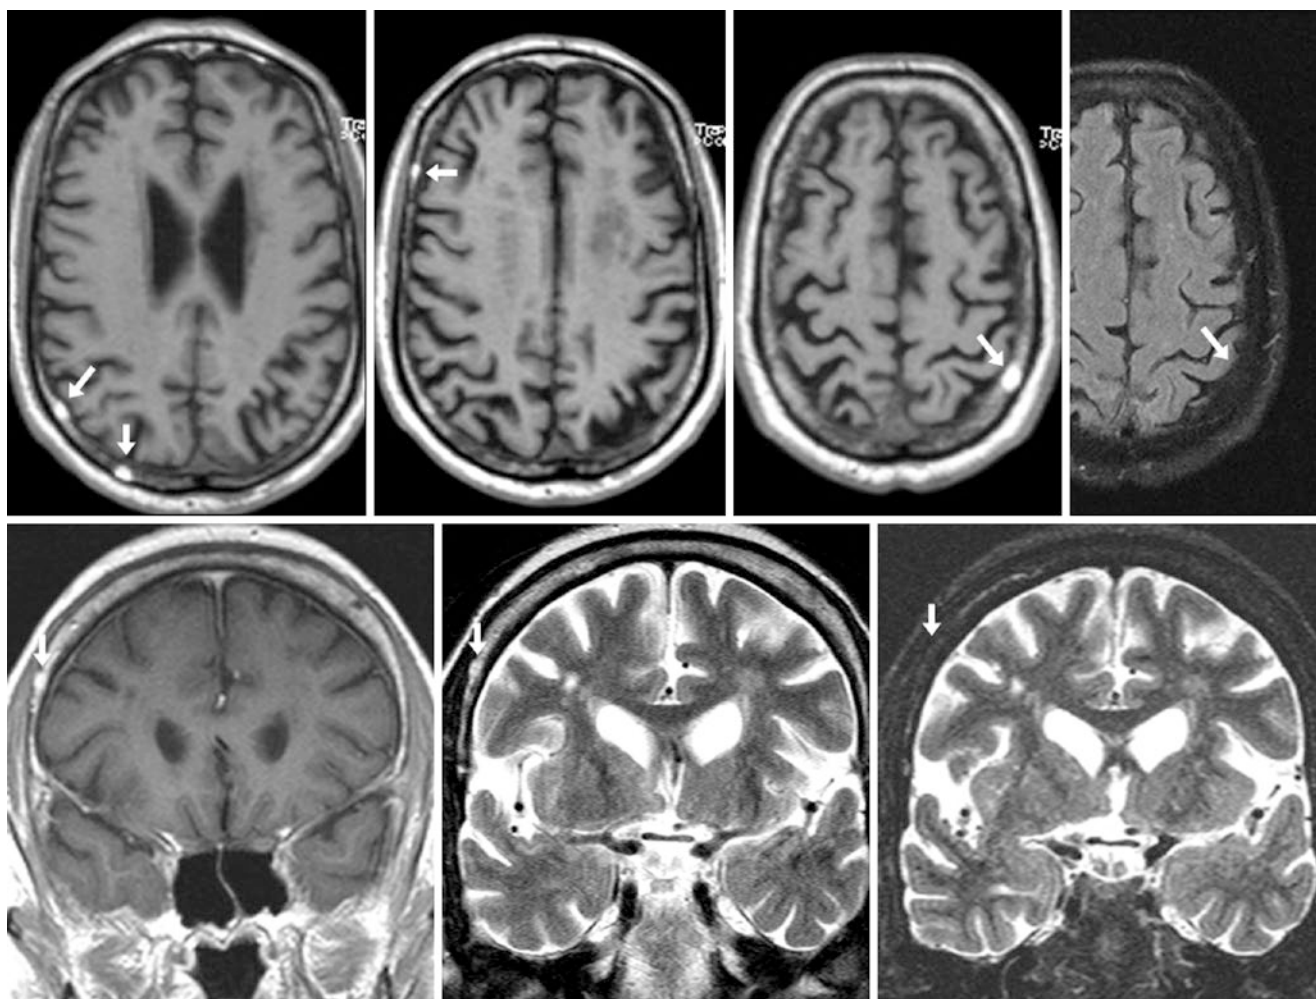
A 59 year old: *Top row:* several small calvarial lipomas (arrows) on gradient-echo T1WI (left three images) have internal fat signal, which darkens on FS FLAIR (right). Focusing on the right frontal lipoma, spin-echo T1WI (bottom left) and T2WI (bottom middle) show that the fat of the T1- and T2-bright component darkens on fat-suppressed T2WI (bottom right)
